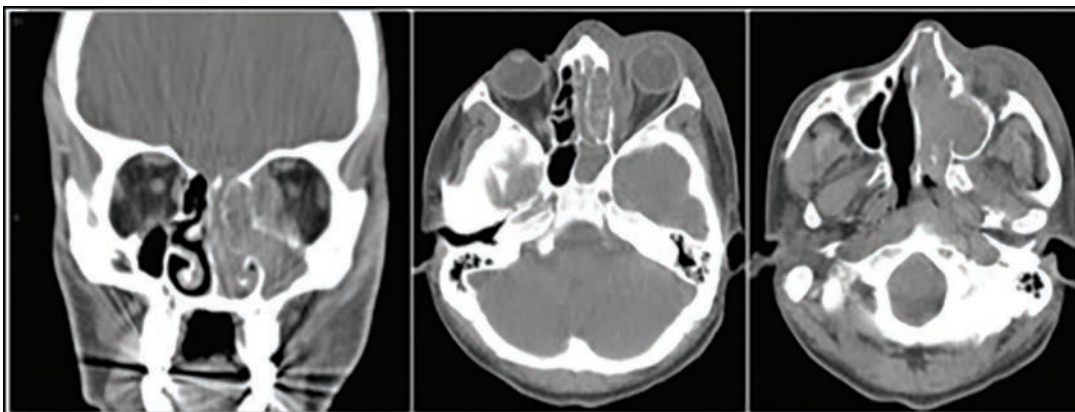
Maxillofacial CT without contrast (soft tissue windows). One coronal and two axial sections demonstrate extensive nasal/sinus cavity disease with complete opacification of left ethmoid, sphenoid and maxillary sinuses, as well as subperiosteal opacification abutting the medial rectus, concerning for left orbital subperiosteal abscess. Note the possible bone erosion on the left.
